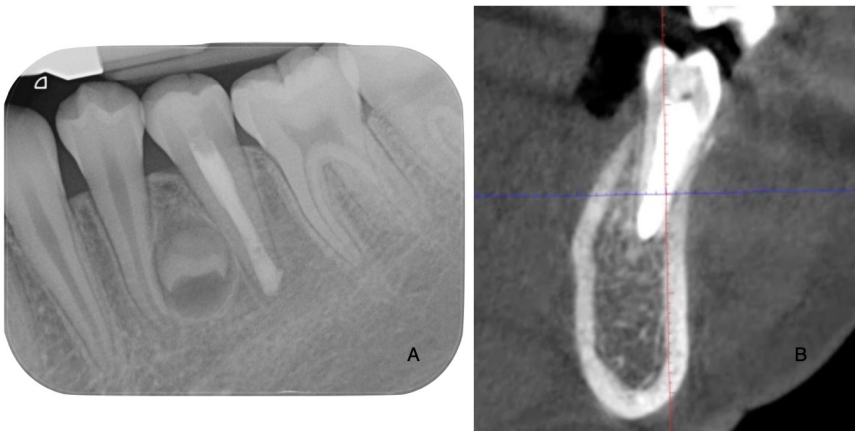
Follow-up periapical radiograph (A) after 10 months and representative CBCT image (B) exhibiting locations of supernumerary tooth highlighting the successful resolution of the periapical lesion, demonstrating the effectiveness of the treatment over time.
